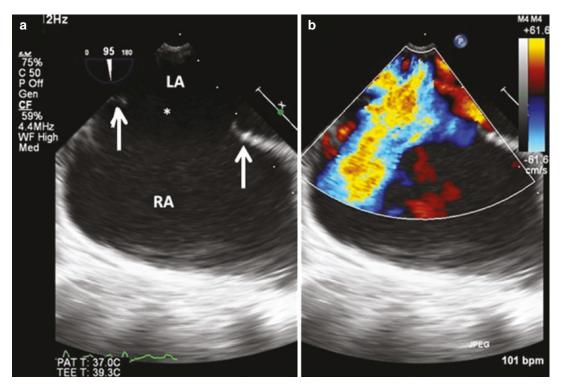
TOE mid-oesophageal cava view. (a) Large secundum type ASD (asterisk). Arrows point the superior and posterior rims of the ASD. (b) Color Doppler shows a broad flow jet directed towards the right atrium
